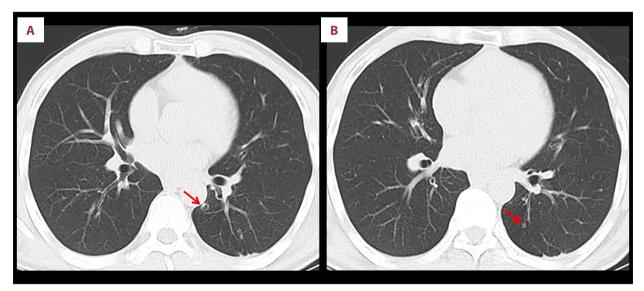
2022.05.25 chest computed tomography (CT) images. (A) As indicated by the red arrow, the larger one was a thin-walled vacuole measuring 0.8×0.7×0.7 cm. (B) As indicated by the red arrow, the smaller one was a solid nodule measuring 0.5×0.4×0.4 cm.
